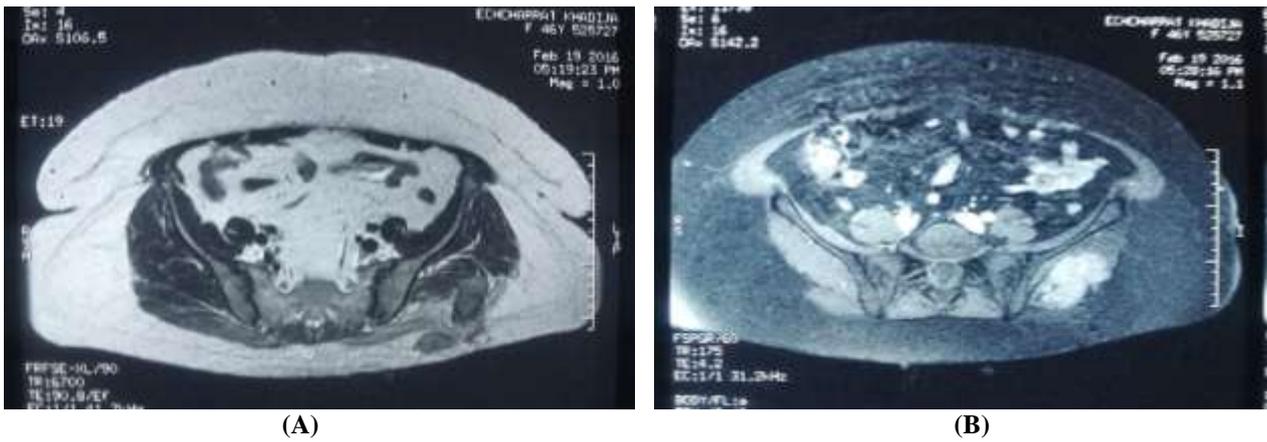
MRI: Cross section: tumor process of the gluteal region left infiltrating the muscles large and medium gluteal, (A): T1 isosignal injury to the muscle with hypersignal zones, (B): Fat-sat Gadolinium: intense contrast enhancement, infiltration of subcutaneous fat.
